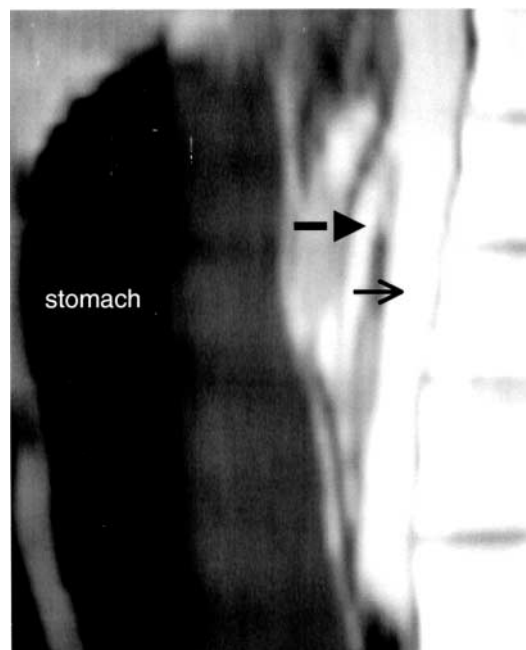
Sagittal CT scan showing narrow angle between aorta (light arrow) and superior mesenteric artery (heavy arrow)
